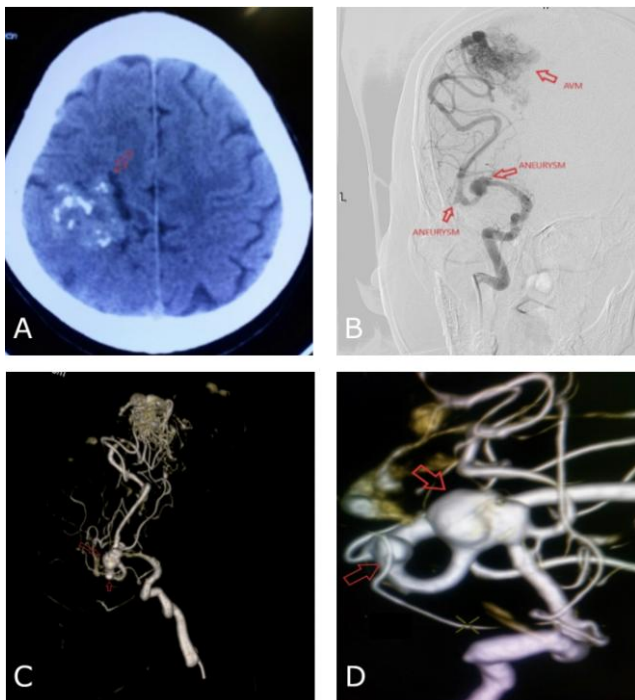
Fifty six year old female patient admitted to hospital due to slight headache; A) Base-line CT Scanner image showed heterogeneous hyperdensity of the right parietal lesion; B) DSA revealed the AVM with main feeding artery from right MCA; C) and D) Morphology and location of two MCA aneurysms
